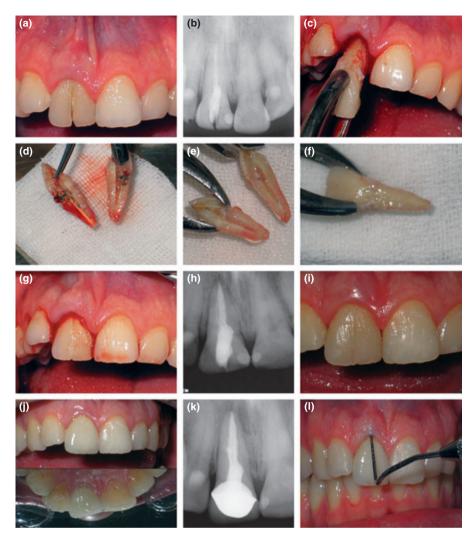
(a) Midline vertical fracture on the right central incisor, (b) preoperative radiographic view of complete vertical fracture extending through the apical region, (c) tooth was extracted with minimal trauma to the surrounding tissues, (d) two separate fragments of the tooth at the time of extraction, (e) root canal filling material was removed with rotary instruments and a shallow preparation was made along the fracture line, (f) two fragments resin-bonded to form one complete tooth, (g) clinical view at 4 weeks following removal of provisional splint, (h) radiographic view at 4 weeks, (i) clinical view at 2 months, (j) vestibular and palatal views of the tooth at 18 months, (k) radiographic view at 18 months.
